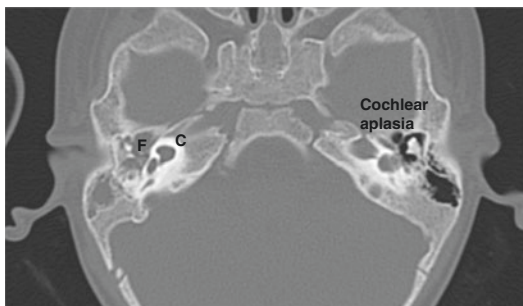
HRCT showing left side cochlear aplasia and right side CH-II with hypoplastic cochlear nerve. On the right side, the middle ear was filled with fluid
